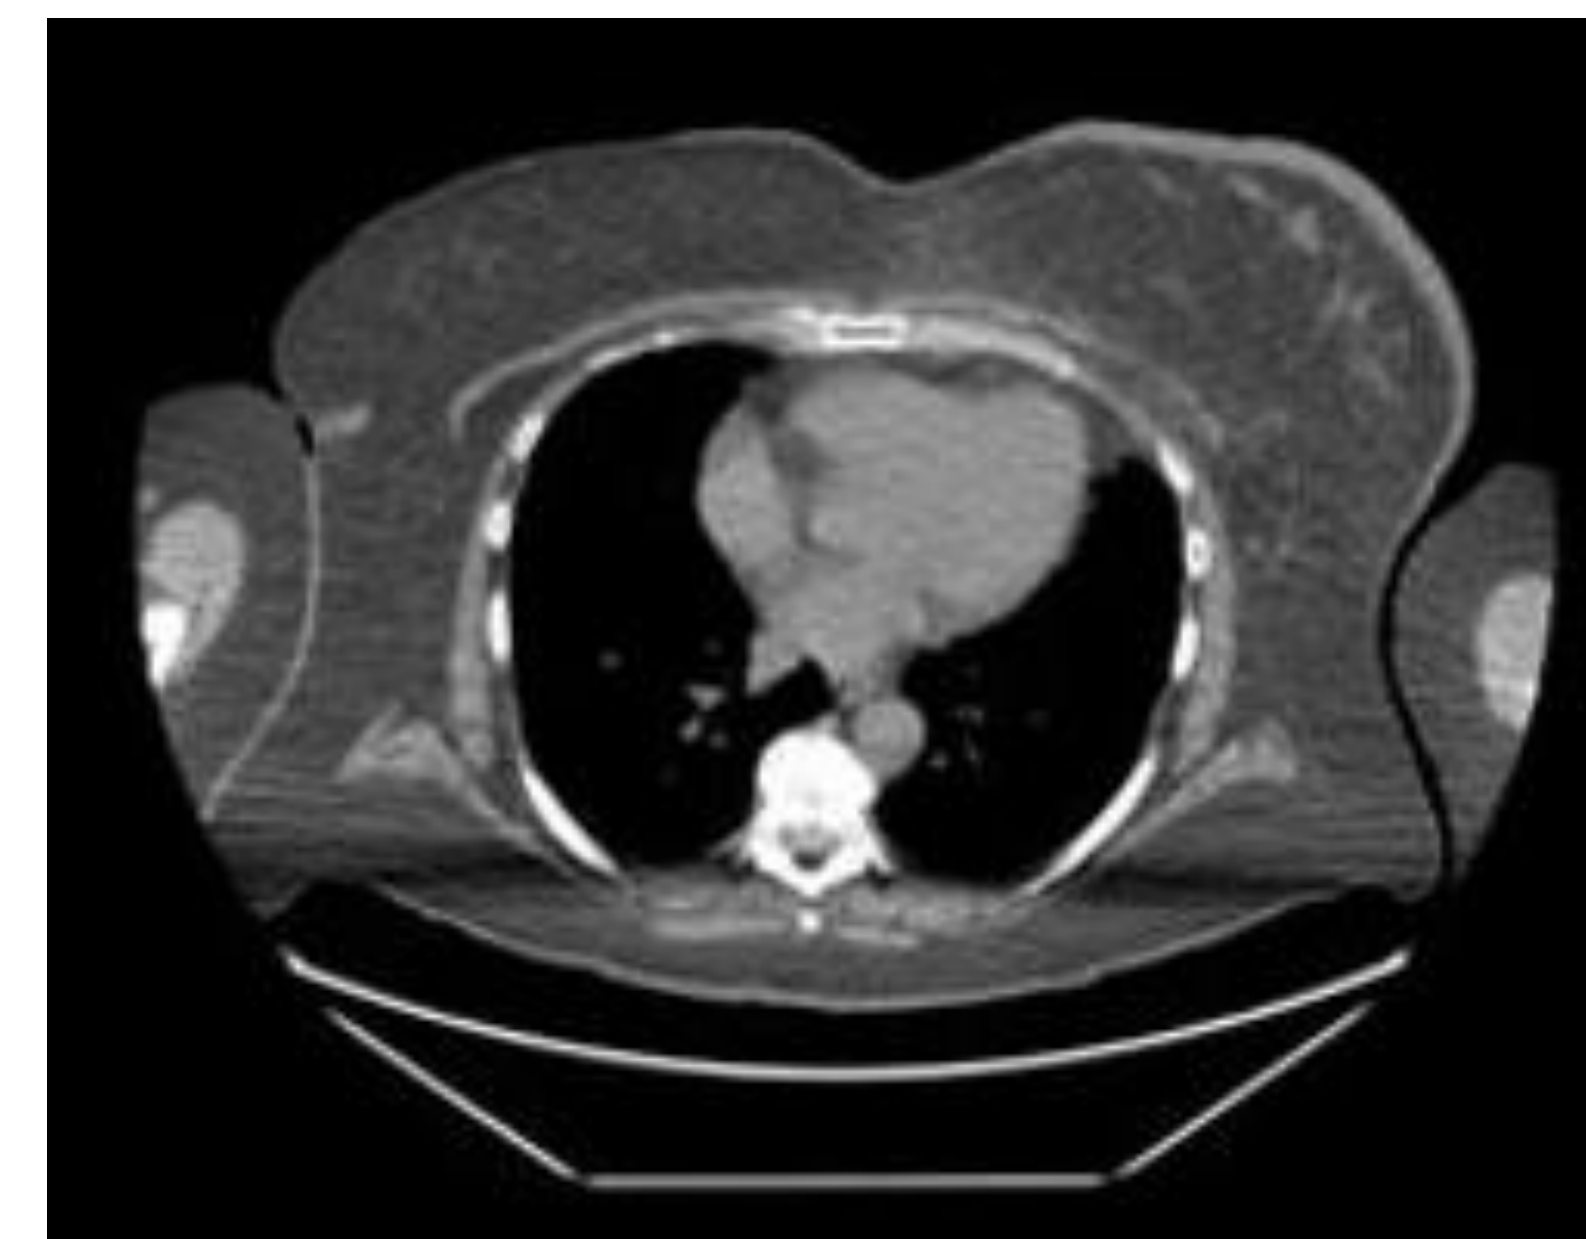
Pre-operative CT findings. Left-sided skin thickening noted on imaging.
